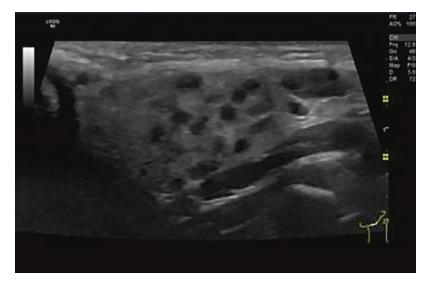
Another case of very characteristic sonographic appearance where the duct of the gland is depicted as dilated due to the existing inflammation
